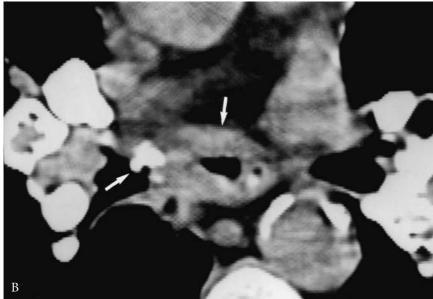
Acquired bronchoesophageal fistula due to broncholithiasis from silicosis involving mediastinal lymph nodes. A, Barium swallow demonstrates a fistula (arrow) from the esophagus to the bronchus intermedius. B, Computed tomography section shows irregular thickening of the esophageal wall (arrow) and a calcified lymph node protruding into the bronchus intermedius (arrow).
